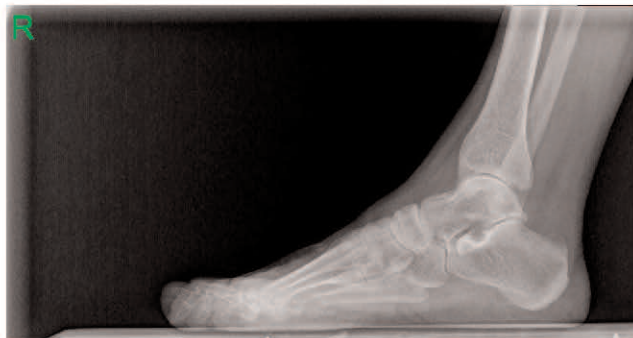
Preoperative lateral weight-bearing x-ray radiography of a 62-year-old woman.
